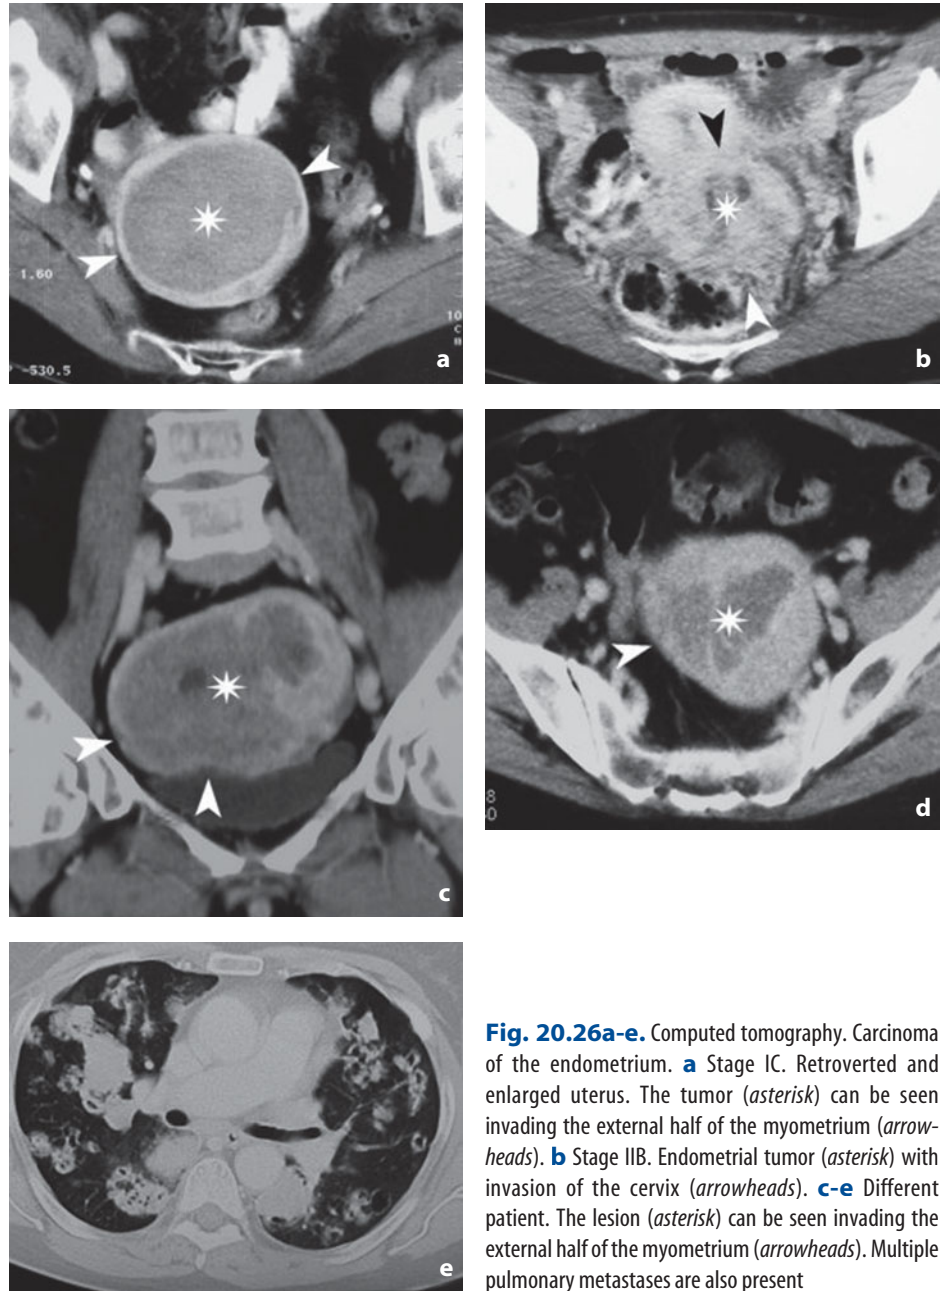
Computed tomography. Carcinoma of the endometrium. a Stage IC. Retroverted and enlarged uterus. The tumor (*asterisk*) can be seen invading the external half of the myometrium (*arrowheads*). b Stage IIB. Endometrial tumor (*asterisk*) with invasion of the cervix (*arrowheads*). c-e Different patient. The lesion (*asterisk*) can be seen invading the external half of the myometrium (*arrowheads*). Multiple pulmonary metastases are also present
